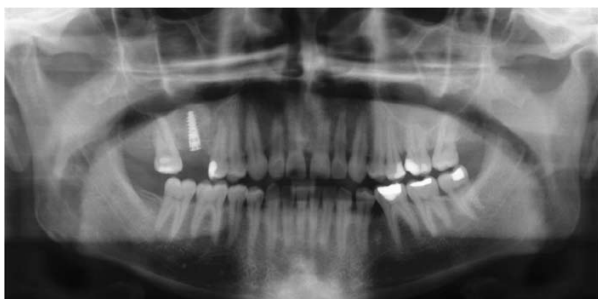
Panoramic radiography before second stage.
